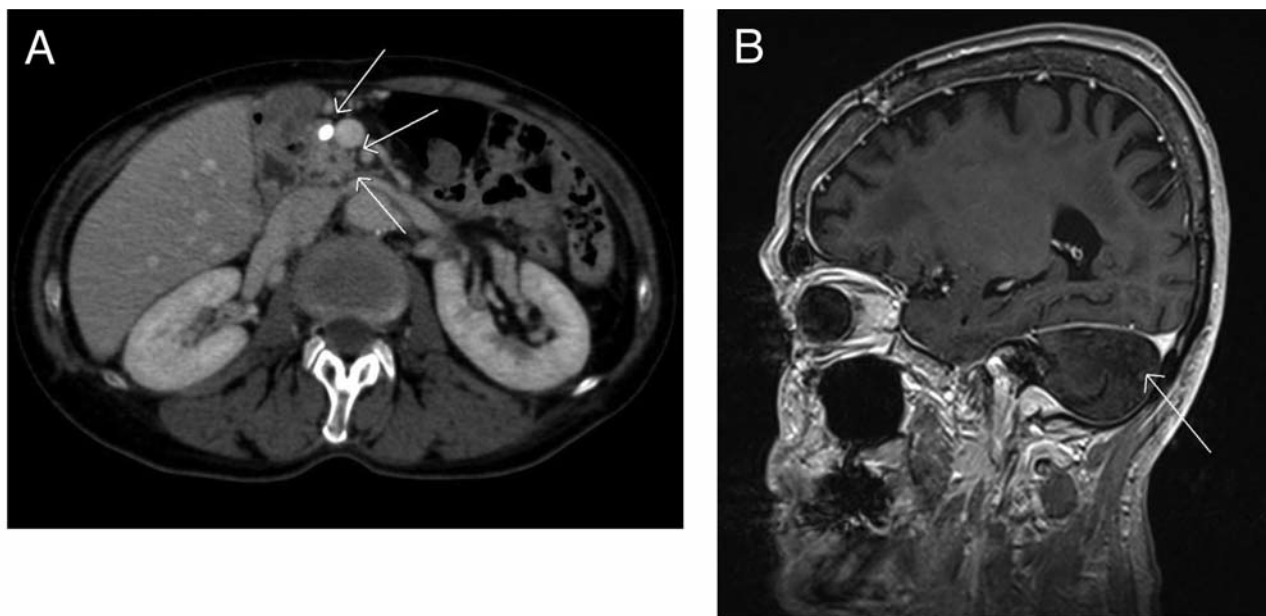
Recent follow-up imaging of abdomen and brain (Case 1). A: Computed tomography of the abdomen (January 2006) performed as follow-up after resection of the pancreatic ductal adenocarcinoma (PDAC) showed the resection margin of the pancreatic corpus (white arrows) with no evidence of tumor recurrence. B: Magnetic resonance tomography of the brain (March 2009) showed postoperative alterations of the right cerebellum (white arrow) but no evidence of tumor recurrence.
